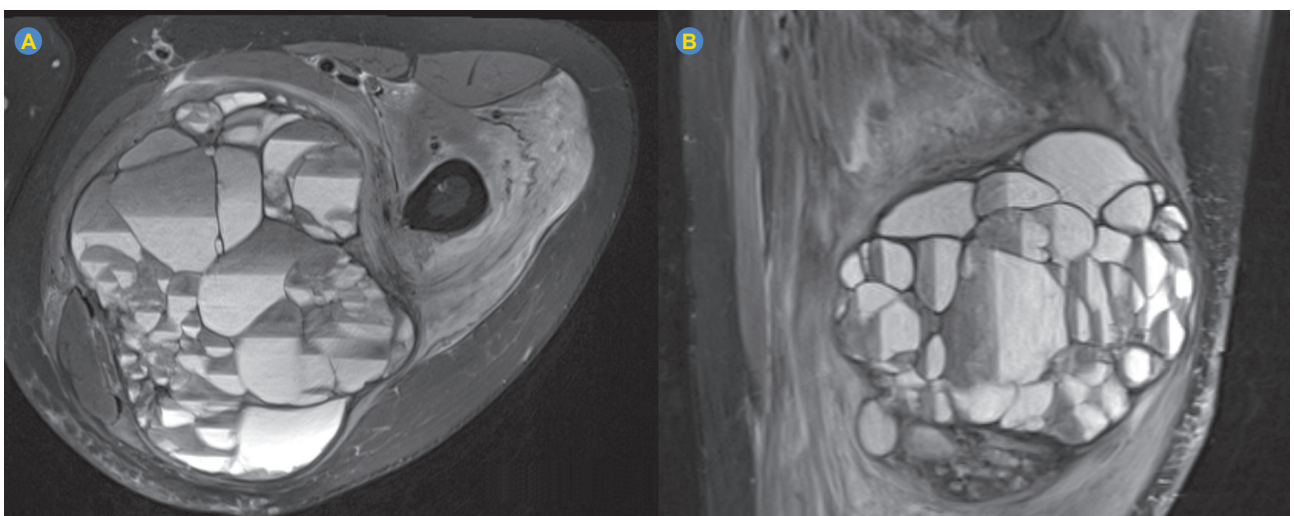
Magnetic resonance imaging of the thigh revealing a multiloculated soft-tissue mass with fluid-fluid levels [axial (A) and sagittal (B) fat-saturated proton density sequences]
